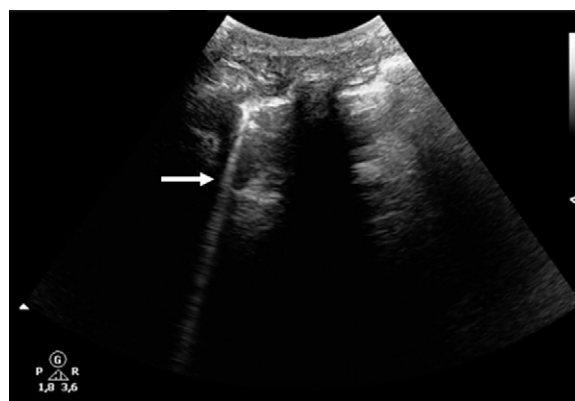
Ultrasound image of lung-comet tail (USLC, white arrow) in a subject on the first day at 4350 m.
